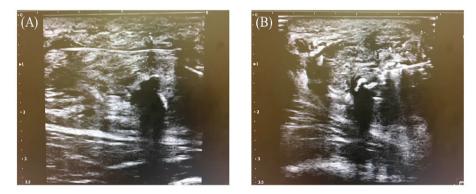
After confirming the sutured site of the Achilles tendon with the long-axis image (A) and the short-axis image (B) under ultrasound, the prepared FD-PFC was dissolved in 3 ml of normal saline and injected into the site.
